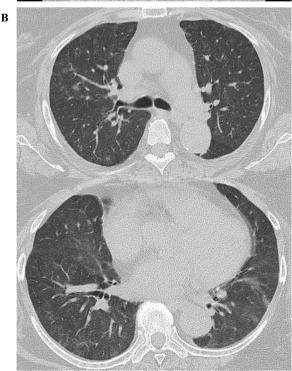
Chest computed tomographic scans after four months treatment with systemic corticosteroids for vasculitis of unknown etiology, showing patchy ground-glass opacities in the lungs (A). Two weeks later, worsening of these shadows is observed (B).
